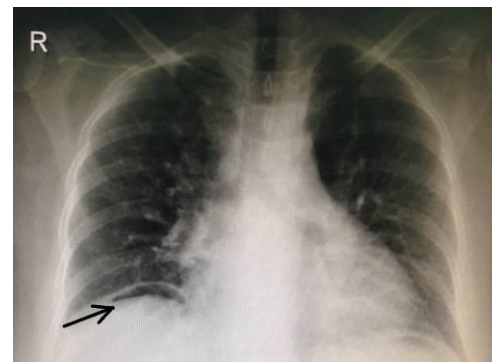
Chest X-ray in erect position showing right sub-diaphragmatic free air (black arrow)
